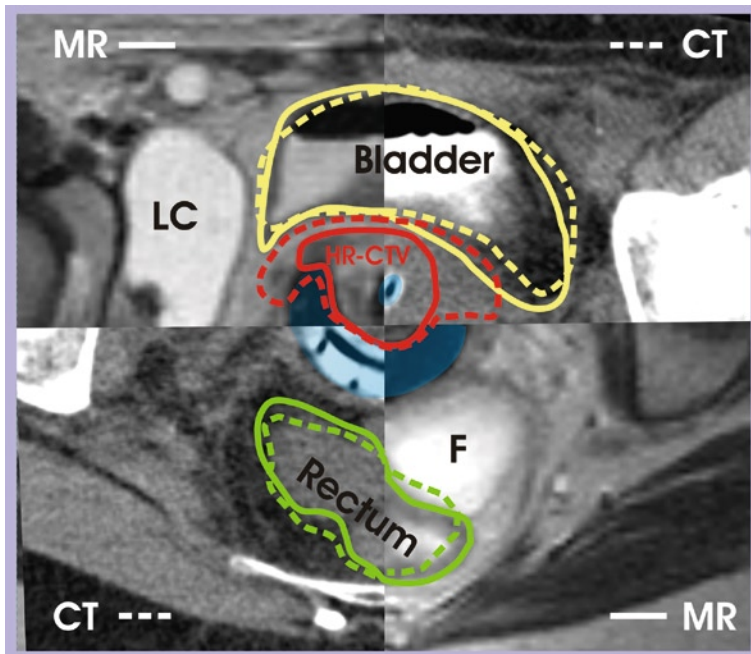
Image fusion between axial computed tomography (CT) and magnetic resonance (MR) scans at time of brachytherapy. Bladder, rectum, and High Risk (HR) Clinical Target Volume (CTV) are contoured (CT – dotted line, MR – solid line). Organs at risk (OAR) contours deviate only slightly, whereas HR CTV is larger on CT, especially in lateral directions. Blue transparent color indicates tandem-ring applicator, which is depicted as a homogeneous black structure in magnetic resonance imaging (MRI). On the contrary, details of the applicator (source channel, holes for needles) are clearly visible on a CT scan (LC, lymphocyst after laparoscopic lymph node staging; F, free fluid in the pouch of Douglas)
